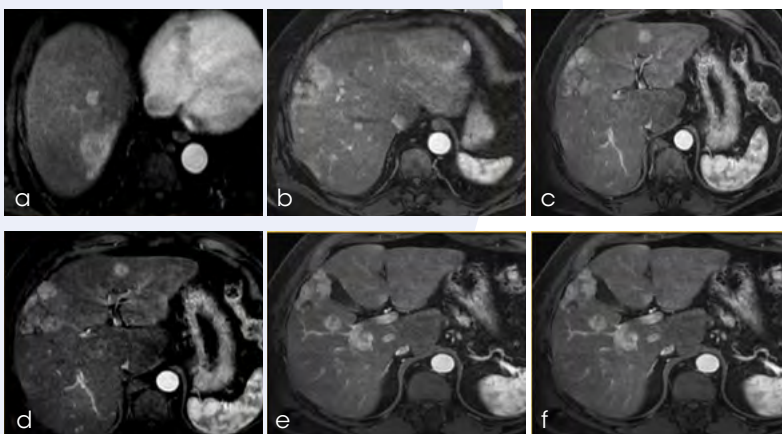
Pre-procedural CT scans show multinodular bilobar HCC lesions (up to 7 cm in size) (a-f)
